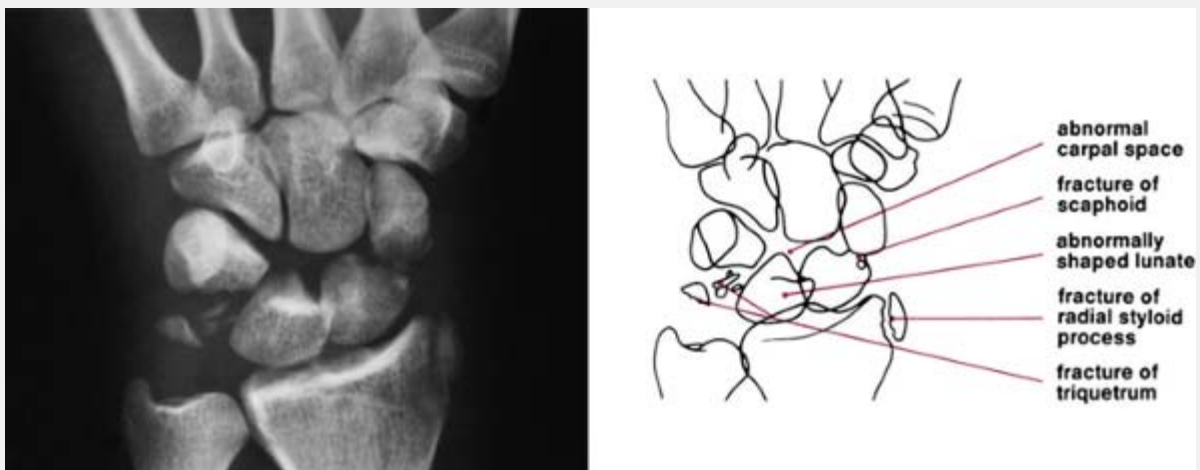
Perilunate dislocation. (A) Lateral radiograph of the wrist demonstrates perilunate dislocation characterized by displacement of the capitate dorsal to the lunate, which, although slightly volarly rotated, remains in articulation with the distal radius. Note the break in the longitudinal alignment of the third metacarpal and the capitate with the lunate and the distal radial surface. On the dorsovolar projection (B), perilunate dislocation is evident from the overlapping proximal and distal
